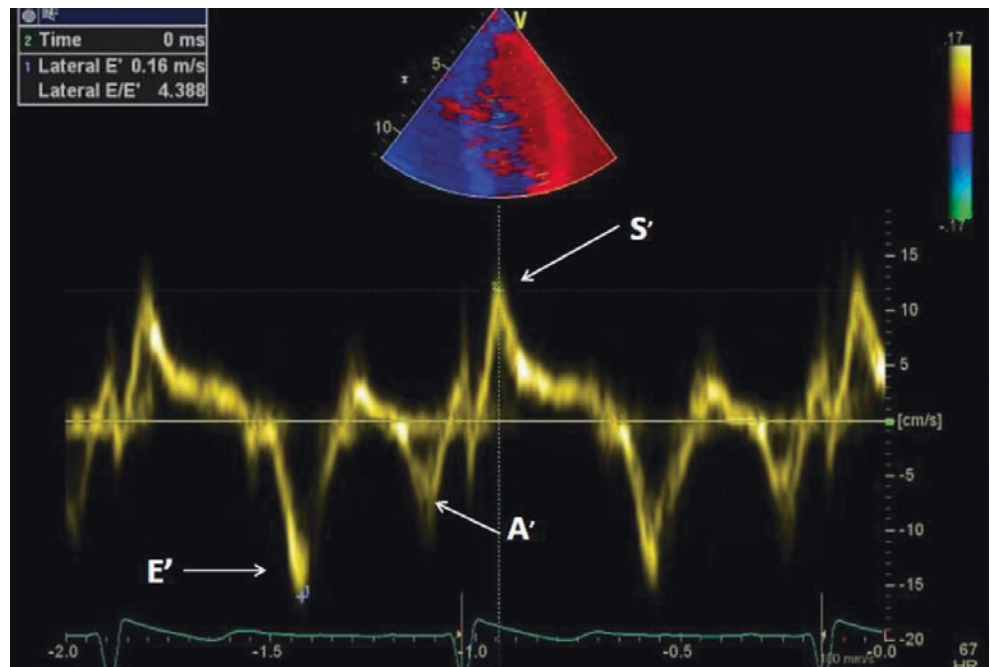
Normal tissue Doppler signals from the lateral mitral annulus. The S' velocity should be >10 cm/s
